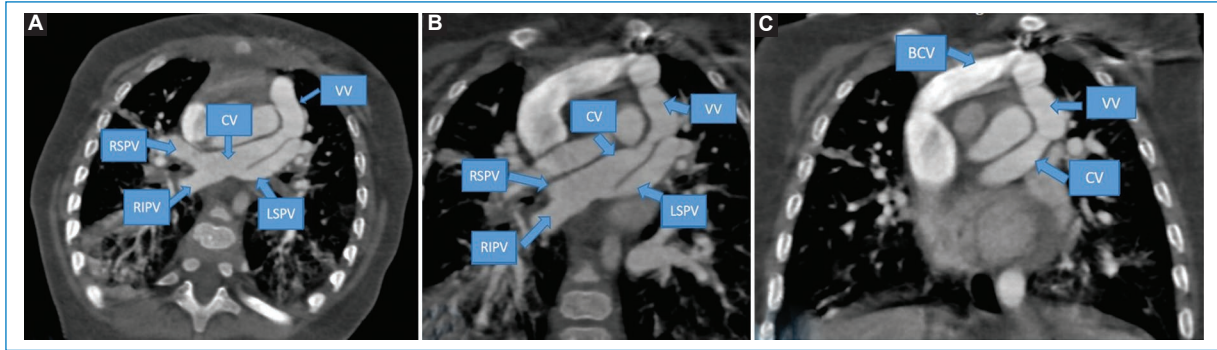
A: magnification of a thoracic CT angiogram in an oblique axial slice, the bone window where it is possible to visualize common drainage of the right superior pulmonary vein (RSPV), right inferior pulmonary vein (RIPV), and left superior pulmonary vein (LSPV) into the collector vein (CV), which communicates with the vertical vein (VV), which drains into the brachiocephalic vein (BCV), as can be seen in B and C, which correspond to magnifications of a thoracic CT angiogram in an oblique coronal slice (*source: WebDiagRX institutional electronic storage system*).
